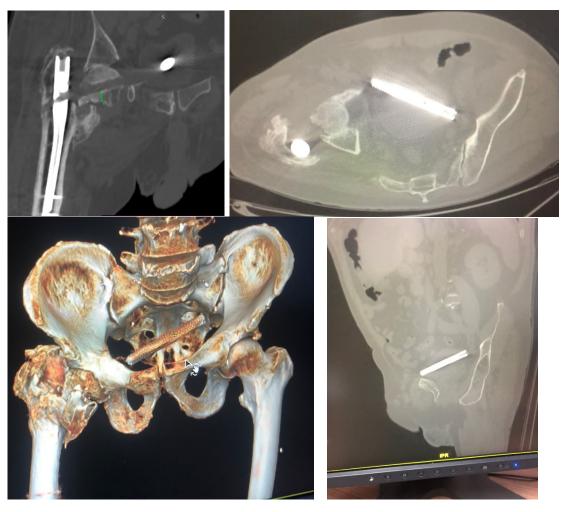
CT of the pelvis: the neck screw of the Gamma nail was freely located in the pelvic cavity, and the threaded part of the screw was directed toward the right hip joint
